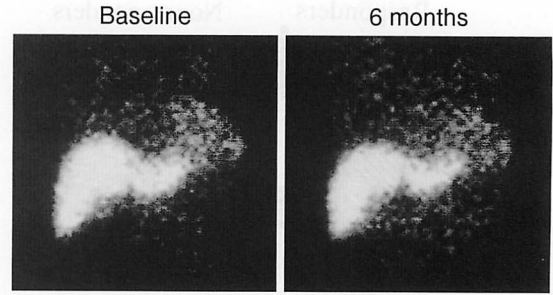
Iodine-123 BMIPP myocardial SPECT planar images before treatment and after 6 months in Nonresponder 4
